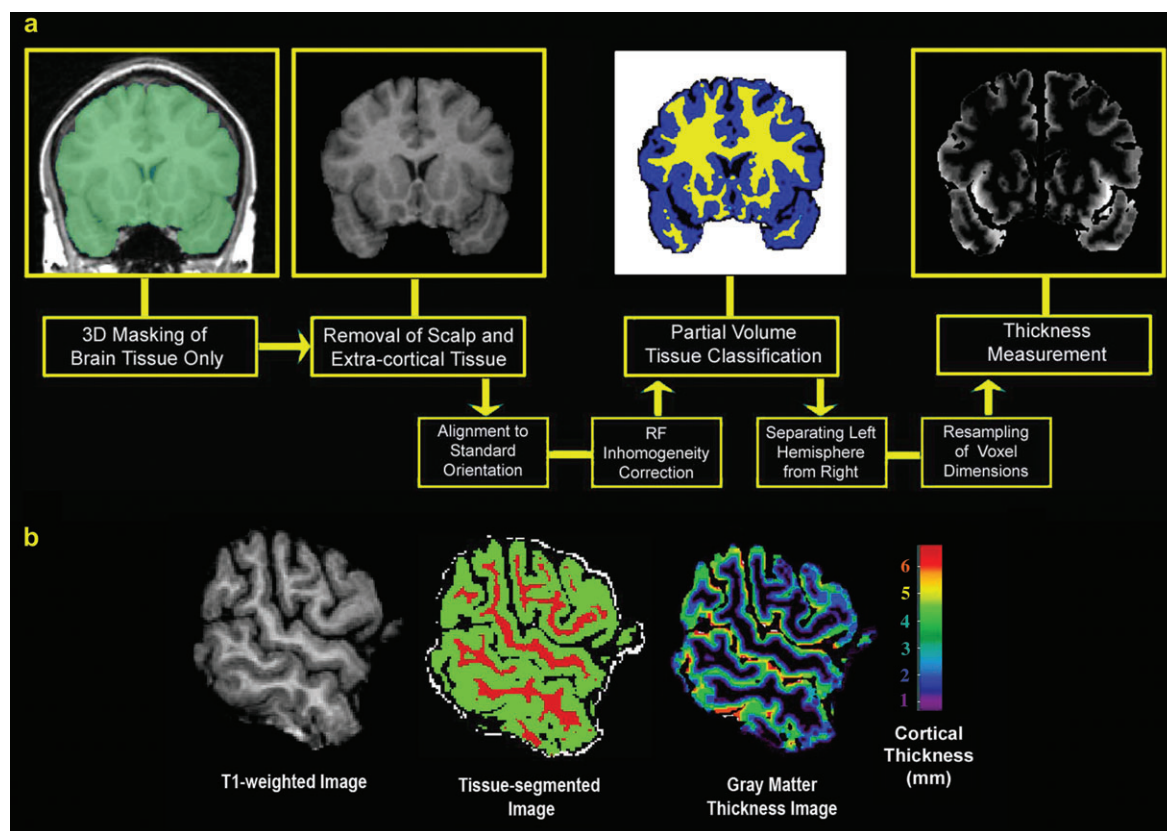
Steps used to generate cortical thickness maps. (a) Series of image processing steps required to derive cortical thickness maps from the MRI scans (see Methods section for details). (b) A sagittal cut from the original T_1 -weighted image for one representative control subject, the tissue-segmented image, and the gray matter thickness image, in which thickness is progressively coded in millimeters from inner to outer layers of cortex using a distance field. RF = radio frequency.
